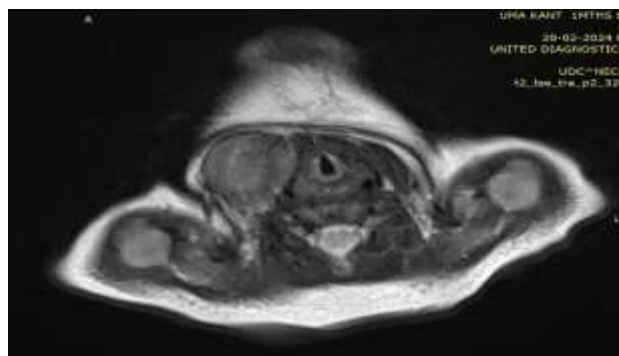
On MRI-neck plain, lesion was iso-intense on T1 weighted imaging and iso-hyperintense on T2/STIR imaging showing maintained fibrillar muscle structure.
